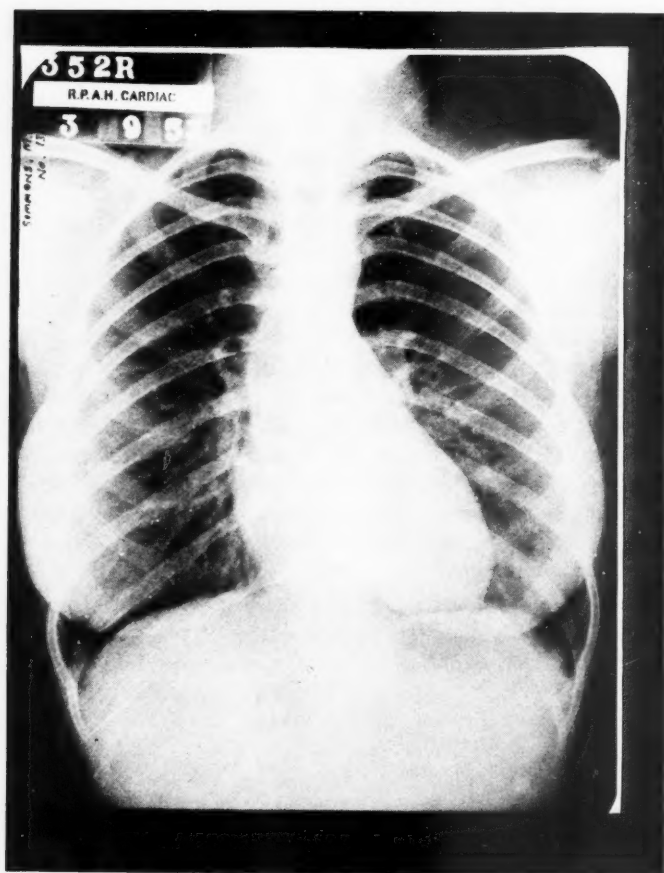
Aortic stenosis, x-ray showing dilatation of ascending aorta.
